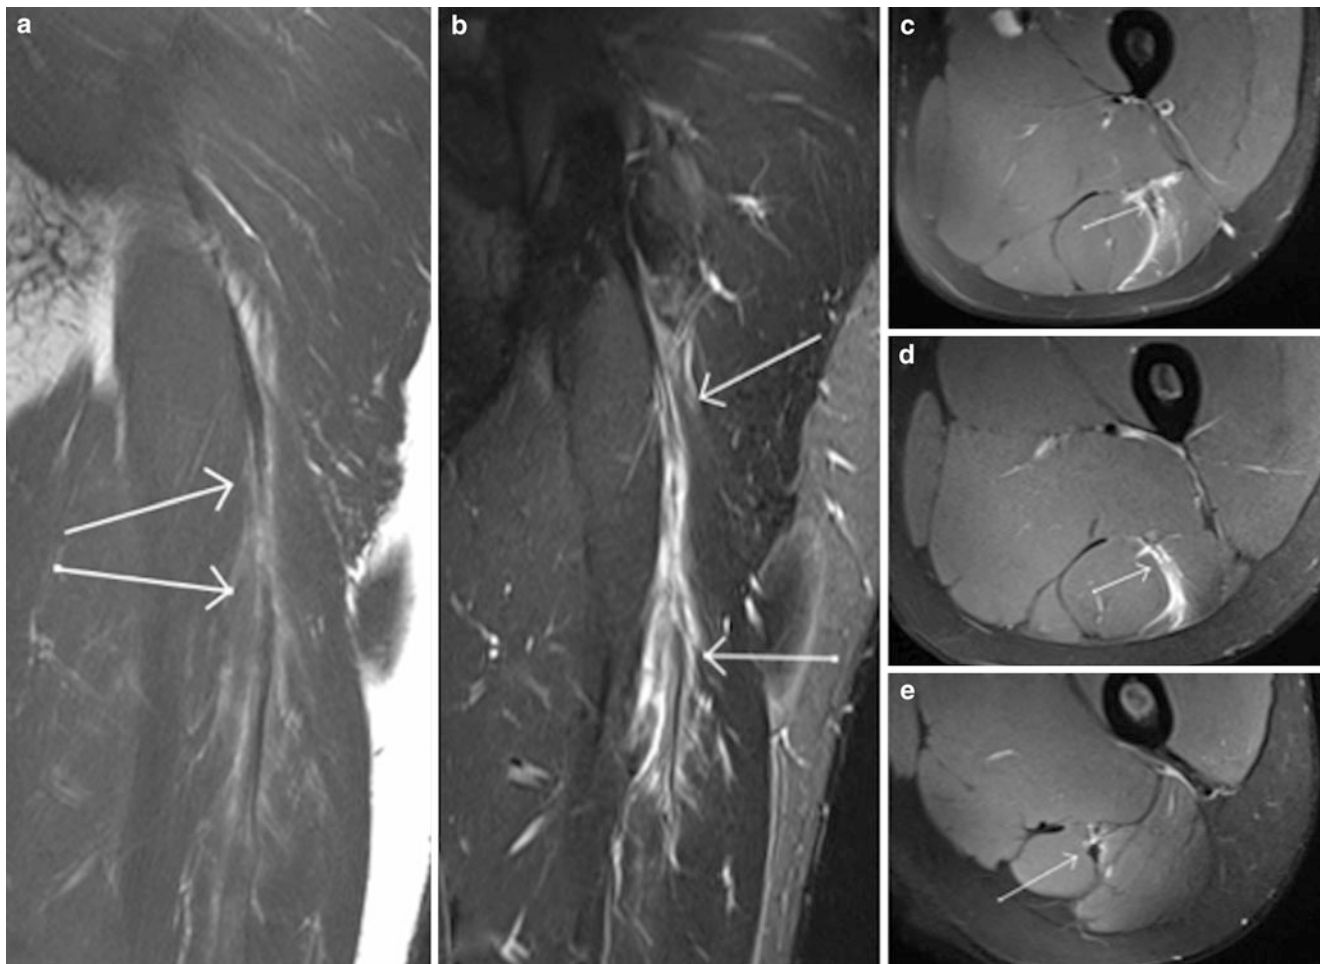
Coronal STIR MR image (a), coronal T2 weighted MR image with fat saturation (b) and axial proton density weighted MR images with fat saturation (c–e) demonstrate an injury to the proximal aspect of the long head biceps femoris with frank tear of the intramuscular
